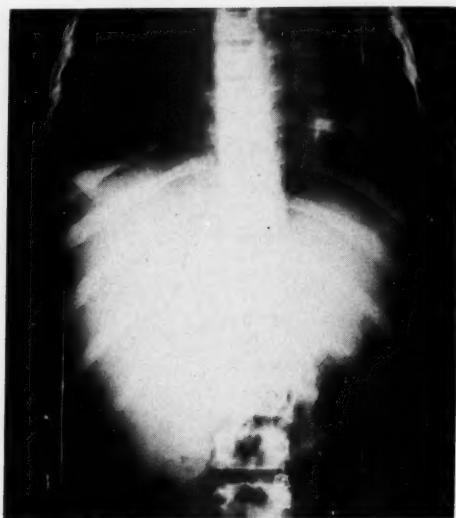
Roentgenogram showing large subcapsular hemorrhage in Case 2.
